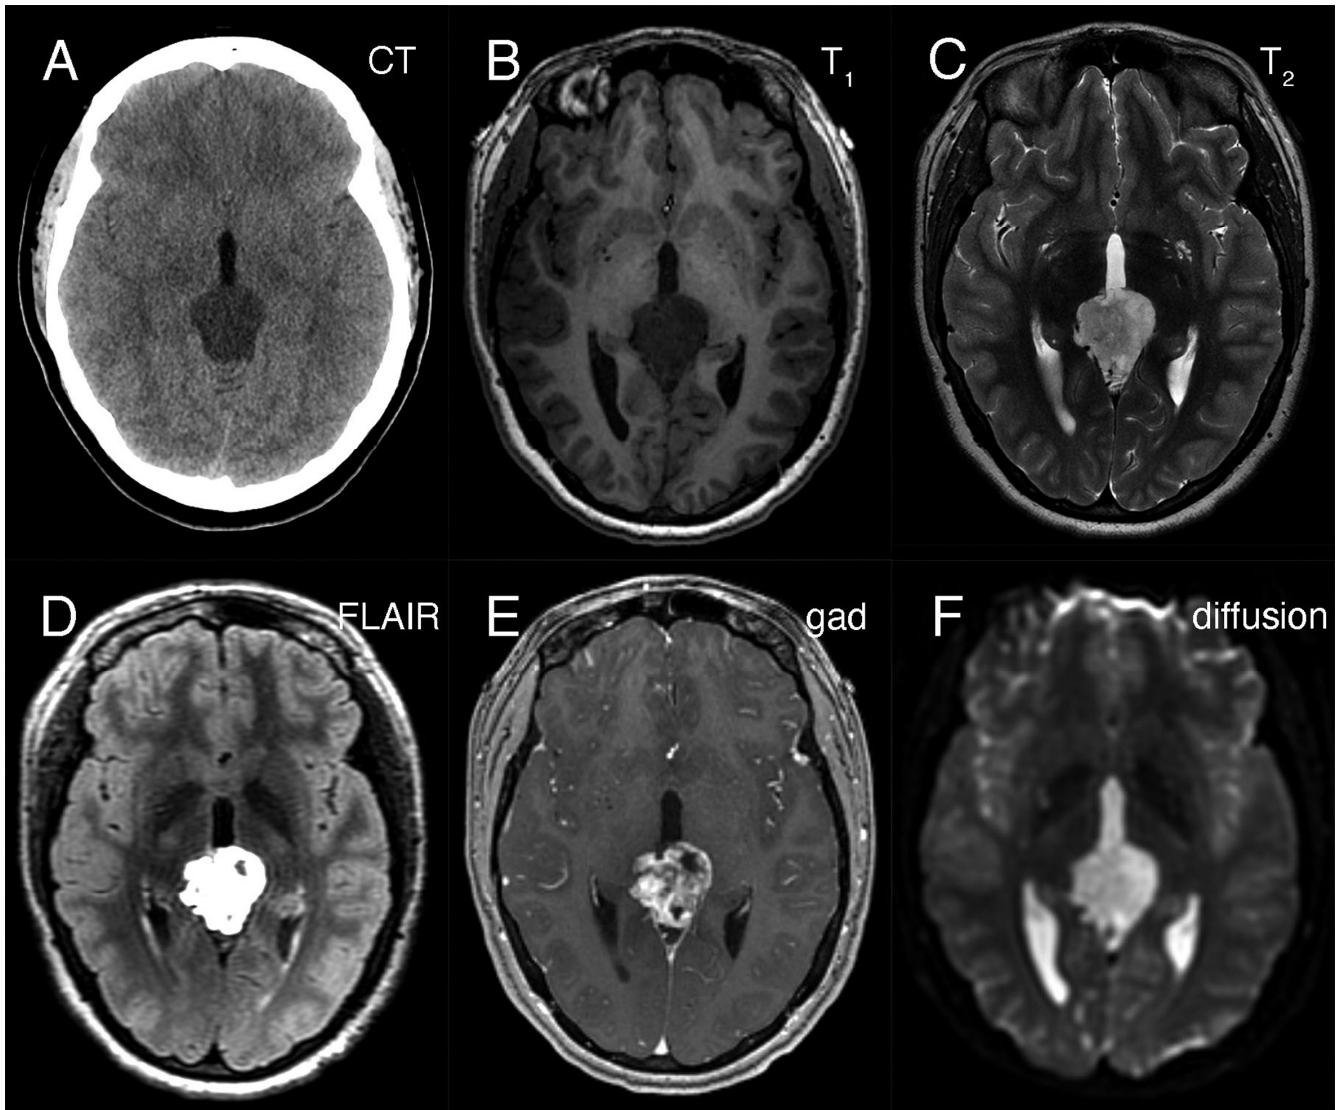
Preoperative neuroimaging. The tumor in the pineal region was hypodense on non-contrast CT head (A), hypointense in T₁-weighted (B) and hyperintense in T₂-weighted (C) MRI sequences. It was strongly hyperintense in FLAIR sequences (D), showed heterogeneous gadolinium enhancement (E), and did not demonstrate restricted diffusion (F).
